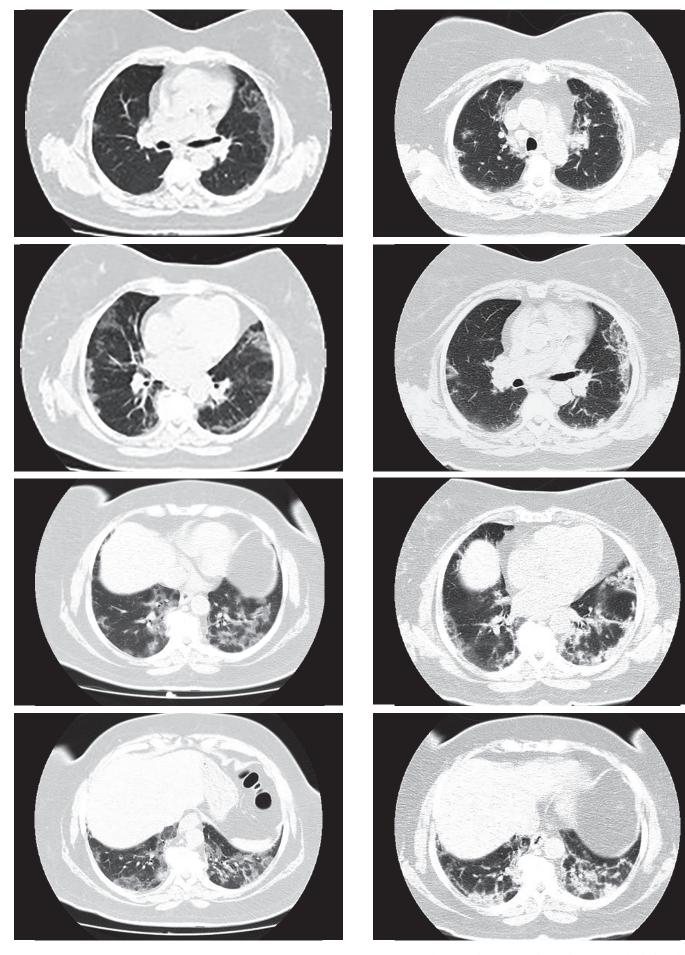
Chest CT at admission showing multiple ground glass opacifications and crazy paving.
